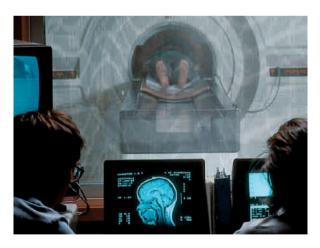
MRI scanning is a noninvasive tool for diagnosing cancer. The patient is placed in a chamber that is surrounded by a magnet. The machine produces a magnetic field in which nuclei of common atoms in the body align and absorb energy. A computer analyzes the information and uses it to generate an image of soft tissues.
